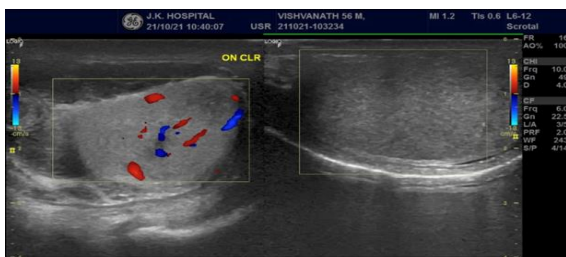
Ultrasound image showing hypo echoic testis with increased Vascularity on color Doppler.
